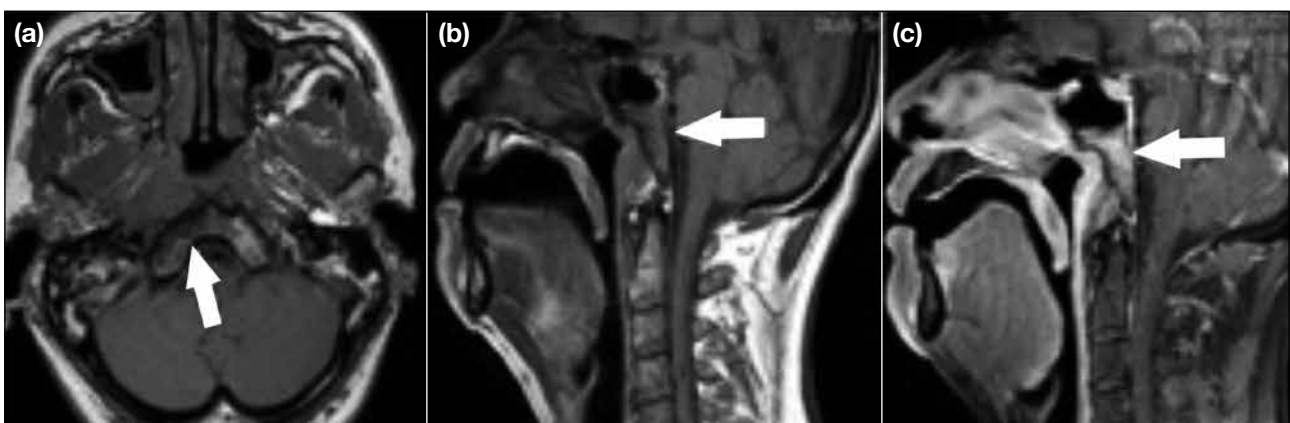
(a) Axial T1-weighted non-contrast magnetic resonance images showing decreased T1 marrow signal at the right side of clivus (arrow). (b) Sagittal T1 non-contrast image. (c) The sagittal post-contrast magnetic resonance image shows contrast enhancement of the clivus (arrows), suggestive of tumour invasion and hence T3 disease.
